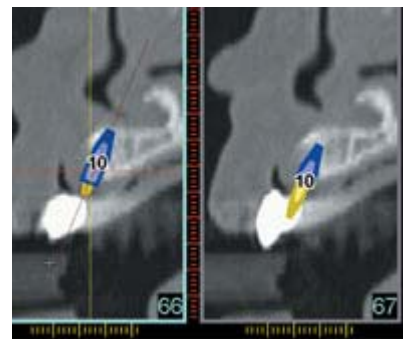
Cross-sectional view of CT showing the need for bone grafting.
